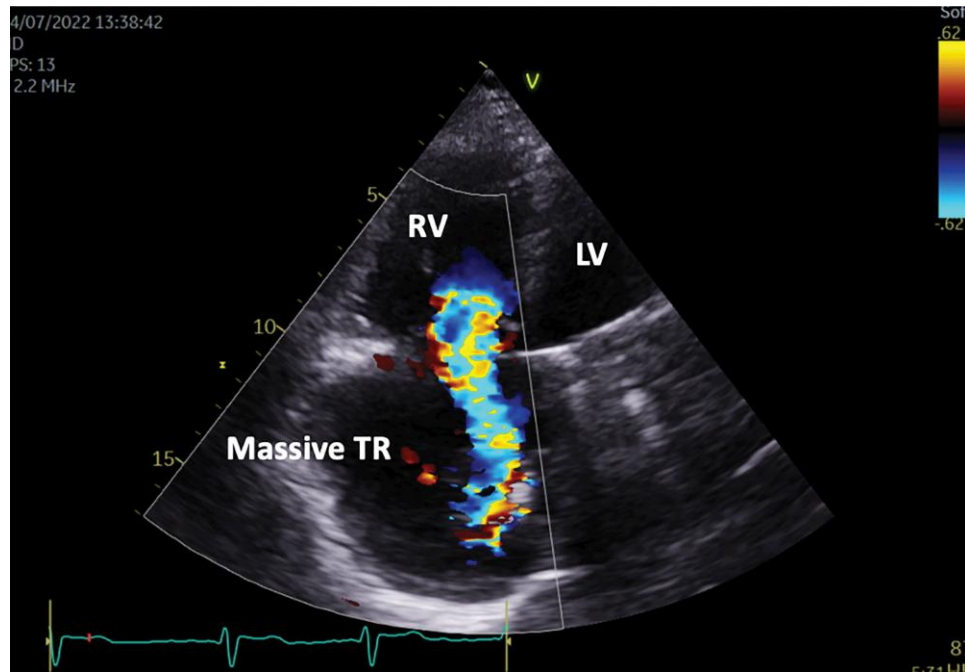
Transthoracic echocardiogram of Patient 2 (apical four-chamber view), showing a massive tricuspid regurgitation. TR, tricuspid regurgitation; RV, right ventricle; LV, left ventricle.
